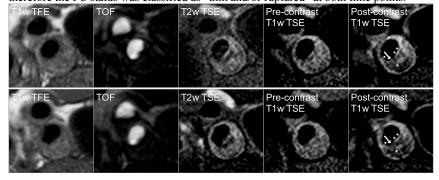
Multisequence MR images of a carotid plaque obtained at baseline (upper row) and at 1-year follow-up (bottom row). At both time points there is high signal intensity on the T1w TFE and TOF images (asterisks), indicating a LRNC with IPH. There is no contrast enhancement between the LRNC and the lumen on the post-contrast T1w TSE images, and therefore the FC status was classified as "thin and/or ruptured" at both time points. At both time points there are calcifications in the outer rim of the plaque, identified as hypointense areas on all MR images (arrowheads in pre-contrast T1w TSE images).
